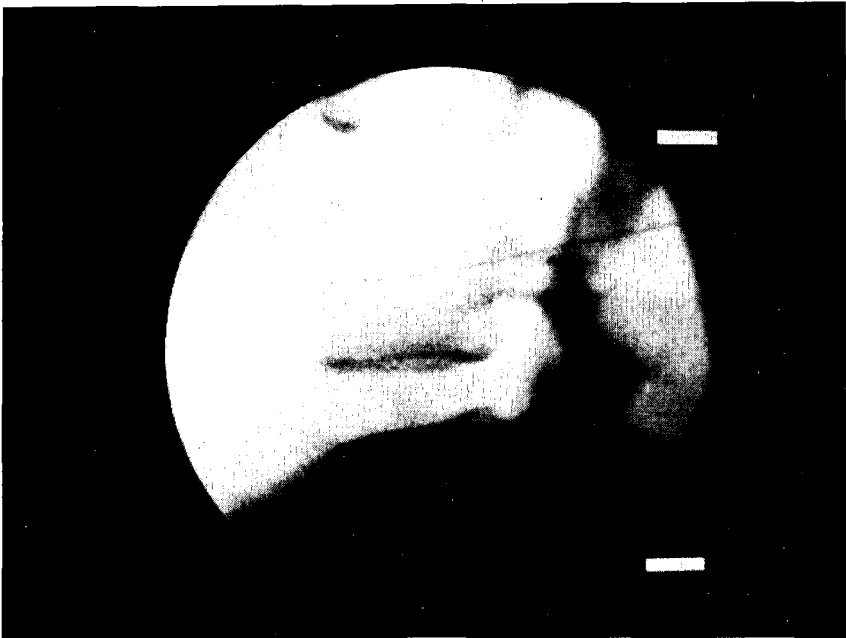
X-ray; lateral view
